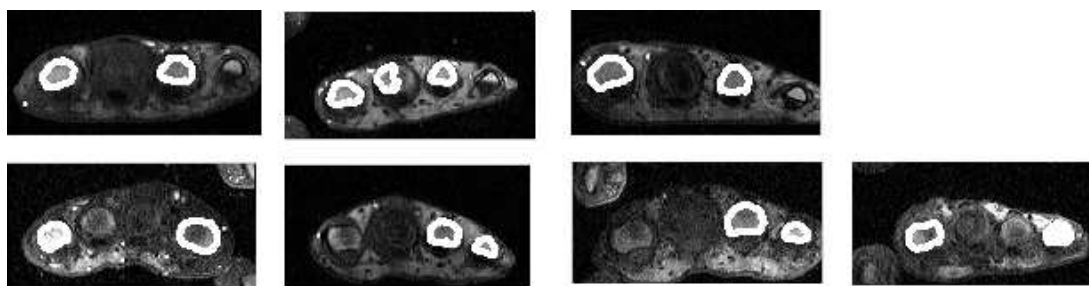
Sample images from different DCE-MRI studies acquired with the high-field scanner. Some bones in these regions were not detected by the algorithm. Contours of the detected bones are shown in white.
